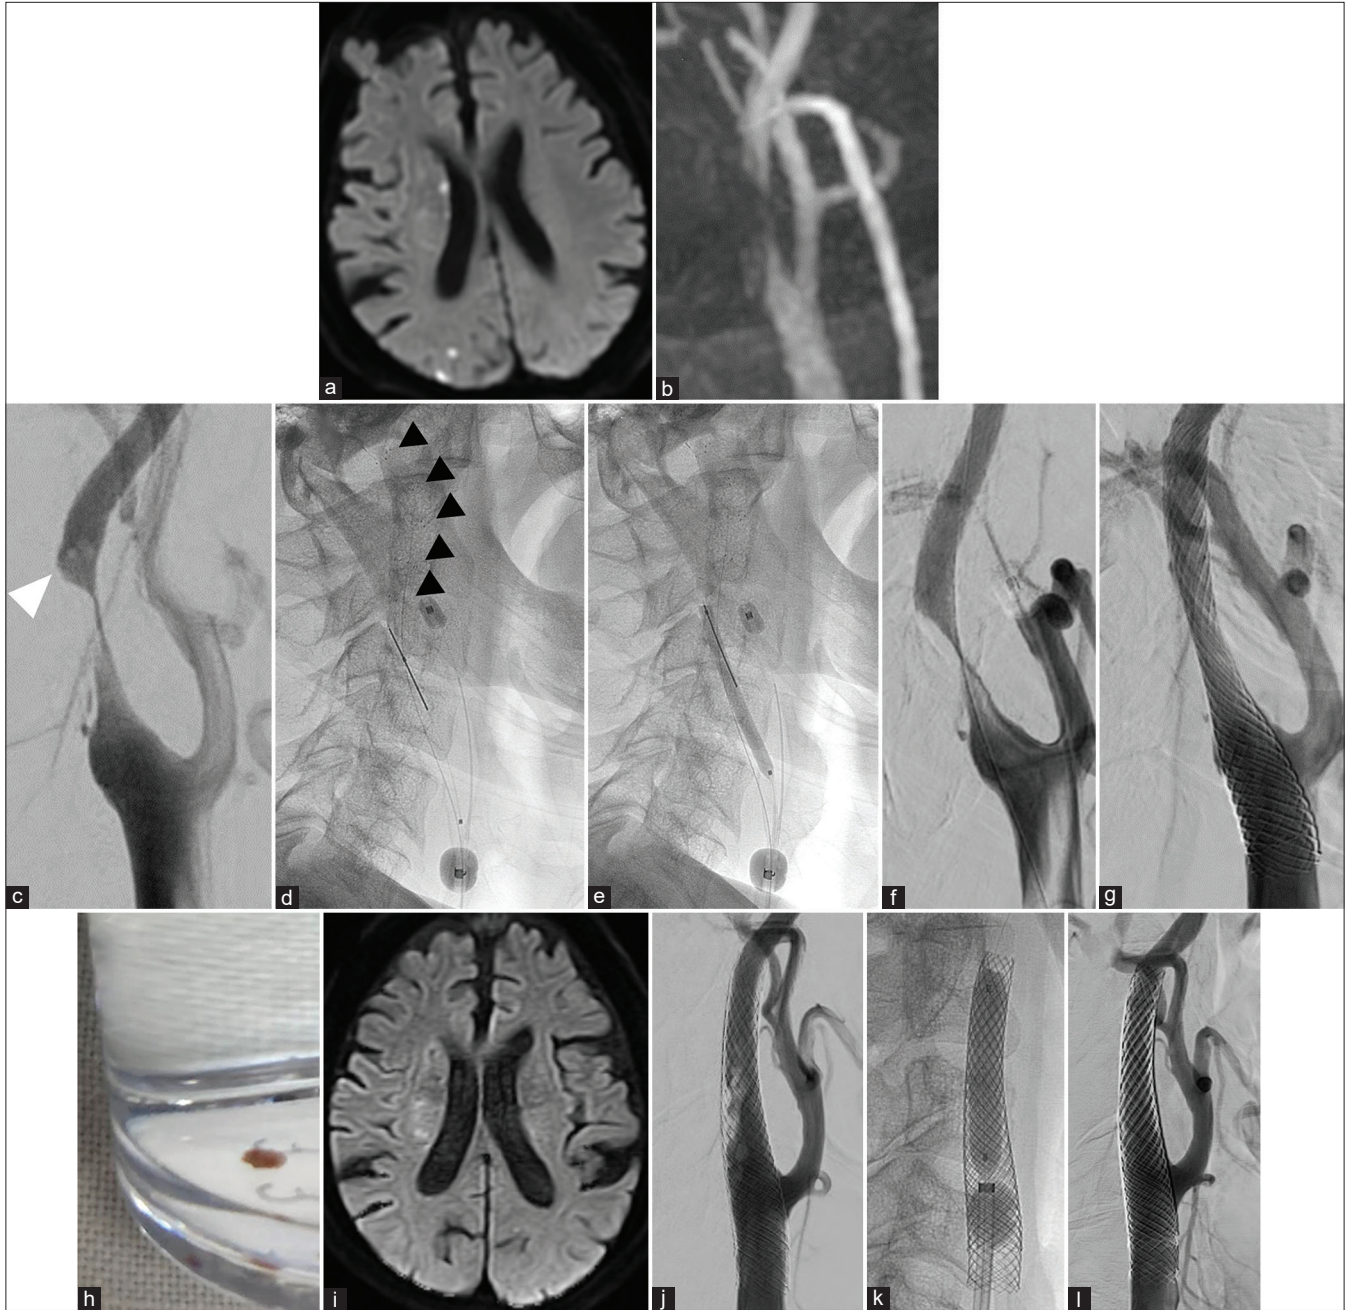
An 81-year-old man with symptomatic right carotid artery stenosis and free-floating thrombus (FFT). (a) Magnetic resonance imaging (MRI) shows diffuse spotty infarctions in the patient's right hemisphere. (b) MRA shows stenosis in right internal carotid artery (ICA). (c) Digital subtraction angiography (DSA) shows severe ICA stenosis with FFT (white arrow). (d) EMBOLTRAP 6.5×44 mm (Johnson and Johnson, Miami, FL, USA, black arrows) is deployed to cover the thrombus. (e) A balloon dilatation catheter guided to the lesion along the push wire of the stent retriever is inflated. (f) After stent retriever retrieval, the thrombus image on DSA disappears. (g) Carotid Wallstent (Stryker, Kalamazoo, MI, USA) is deployed. (h) White thrombus retrieved by the stent retriever. (i) Postoperative MRI shows no increase in infarction. (j) DSA shows recurrence of in-stent plaque protrusion after additional stent placement. (k) Balloon dilation with proximal balloon protection and distal filter protection. (l) Final image after placement of the third stent (10×30 mm CASPER Rx, Microvention, Tustin, CA, USA).
